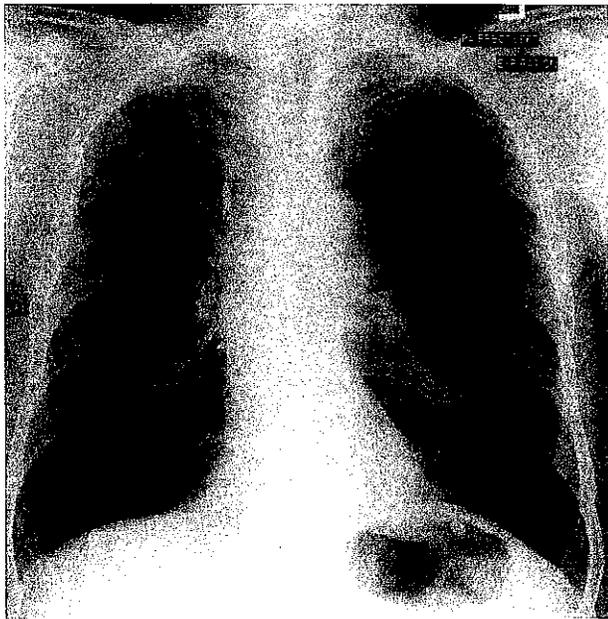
A chest X-ray showing a stent in position in the right main bronchus.
